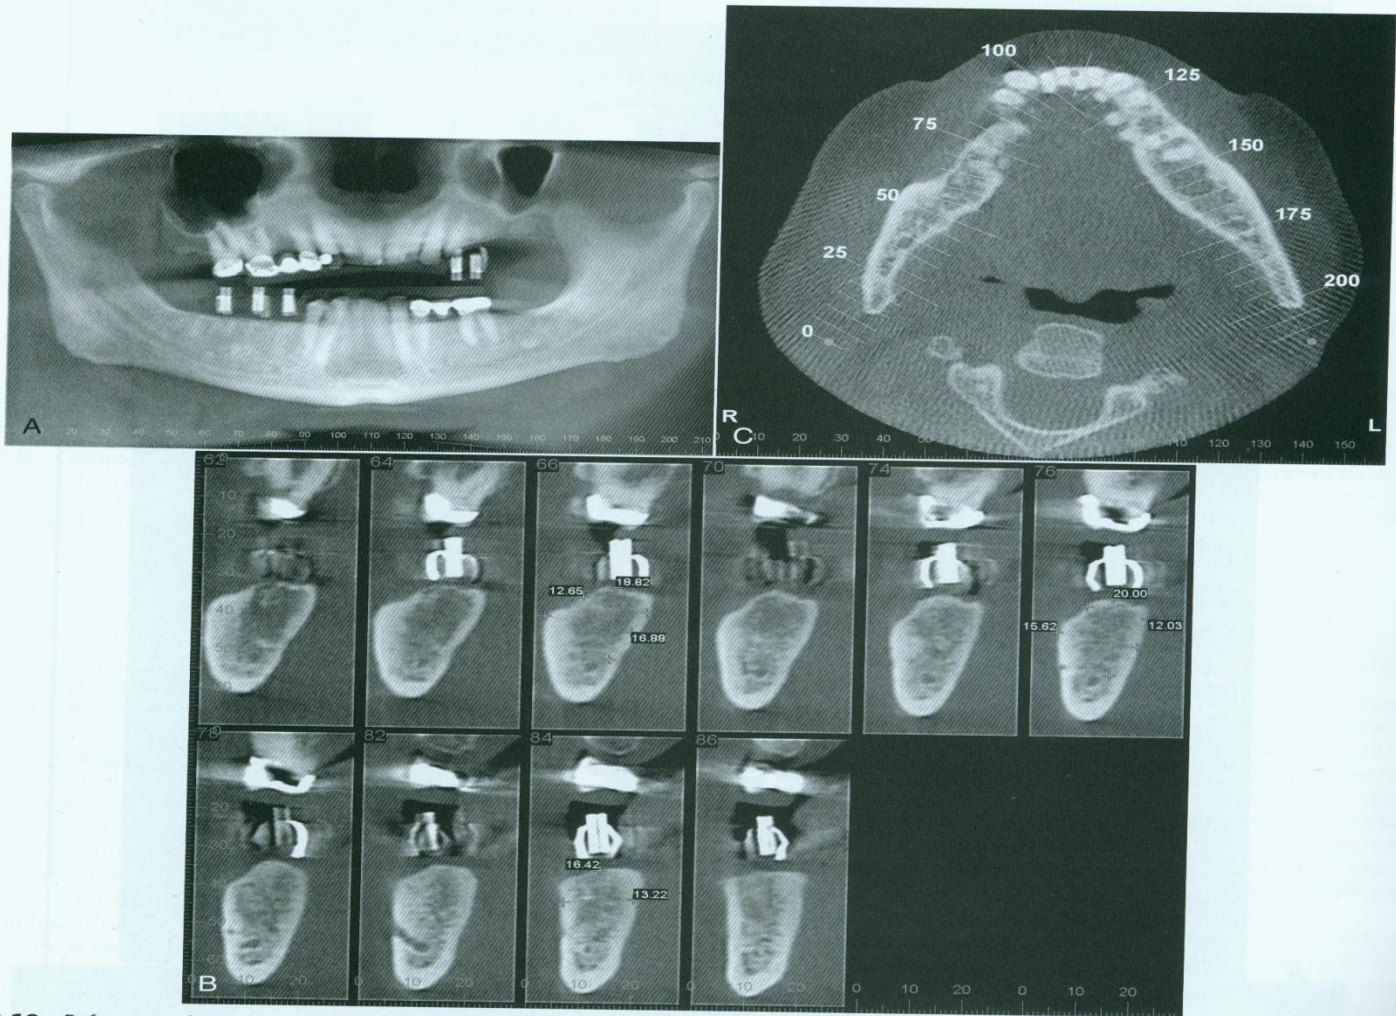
Reformatted cone-beam CT study of the mandible. A, Panoramic-like curved linear reconstructed image. The imaging stent incorporates copper cylinders for the path of insertion and radiopaque strips defining the buccal and lingual contours of the proposed prosthesis. The copper cylinders will allow the imaging stent to be used as a surgical guide when the implants are placed. B, Correlating cross-sectional images. C, Reformatted axial image through the alveolar ridge depicting the panoramic arc and correlated cross-sectional images. (Courtesy Oral and Maxillofacial Imaging Center, Baylor College of Dentistry, Dallas, Tex.)
